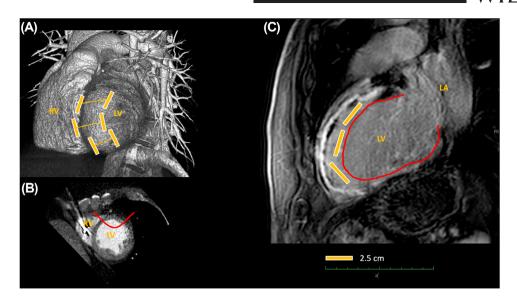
CT scan: (A) case planning according to scar location on 3D volume rendering; (B) RV-LV basal "Antonius" stitch, addressing additional antero-lateral and septal components of the scar; (C) expected result of preoperative LGE CMR (red line). Anchors are represented by yellow rectangles. LA, left atrium; LV, left ventricle; RV, right ventricle
